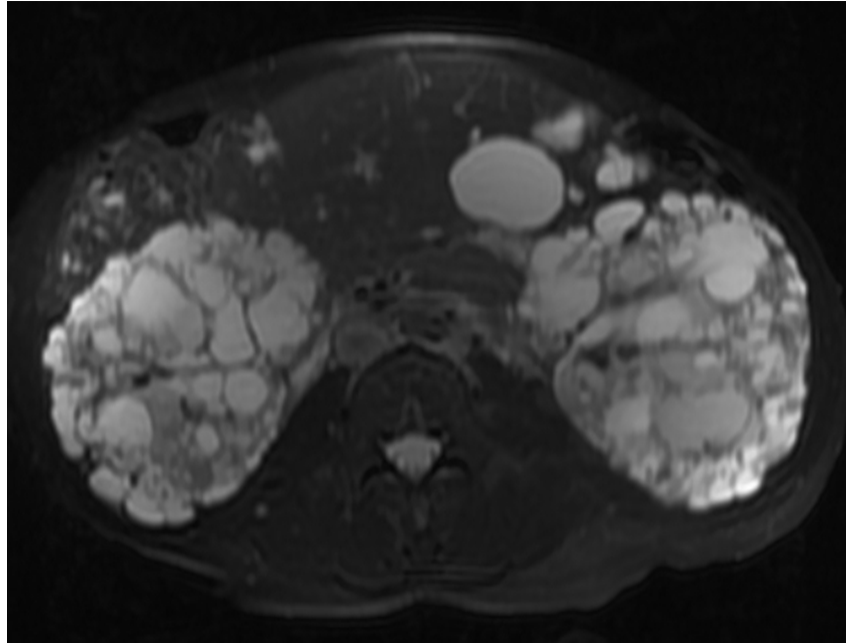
T2 phase MRI of the abdomen and pelvis of a patient affected by autosomal dominant polycystic kidney disease (ADPKD). Both kidneys are affected by multiple cysts of different size. Normal renal parenchyma can be found in the space between the renal cysts. The pressure generated by the fluid that fills the lumen of the cysts progressively compresses normal renal tissue and, over time, 40-50% of patients affected by ADPKD can progress to end stage kidney disease (4). Contrary to autosomal recessive polycystic kidney disease (ARPKD), the renal cysts in ADPKD develop in any part of the nephron and involve the medulla as often as the cortex. Because ADPKD is a progressive disease, most patients are born with normal kidney and a normal ultrasound examination cannot exclude ADPKD until after the age of 35 (5), especially for patients with PKD2 mutations which are associated with later disease onset.
